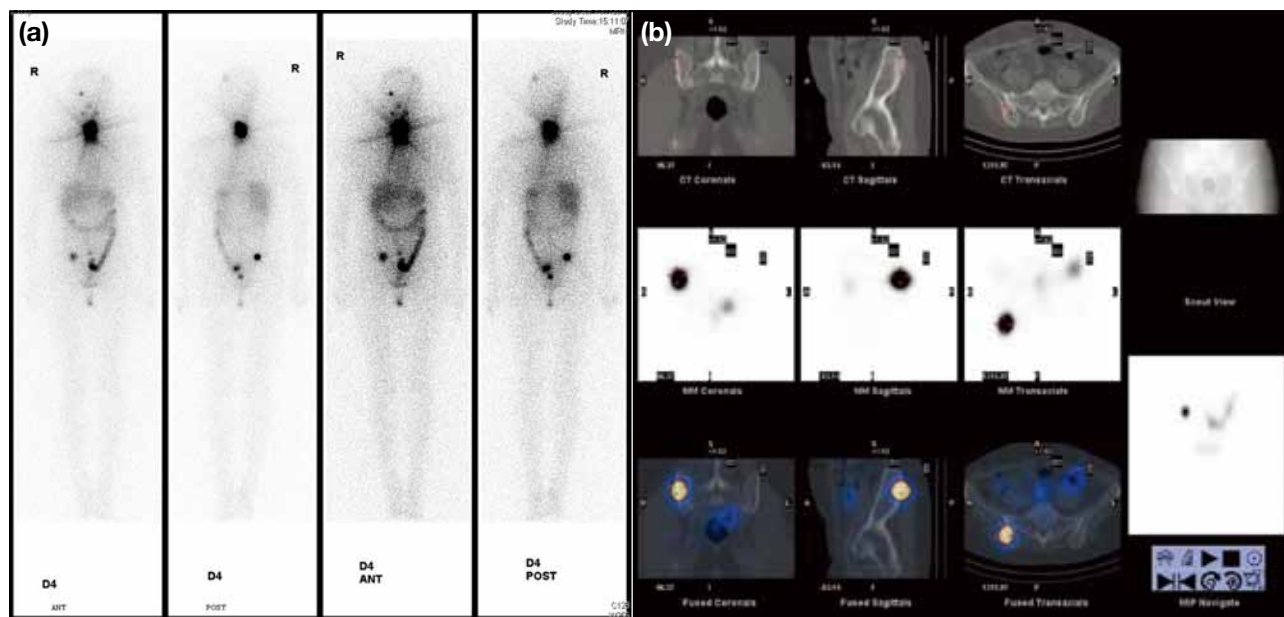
(a) Whole-body biplanar scintigraphy shows a blooming artefact in the thyroid bed suggestive of residual malignancy, intense uptake in the right fronto-orbital and left posterior parietal bones of the skull suspicious of metastases, and equivocal intense uptake in the right lower quadrant of the abdomen. (b) ^{131}I -SPECT/CT fusion images show distant bony metastasis in the right posterior ilium.
